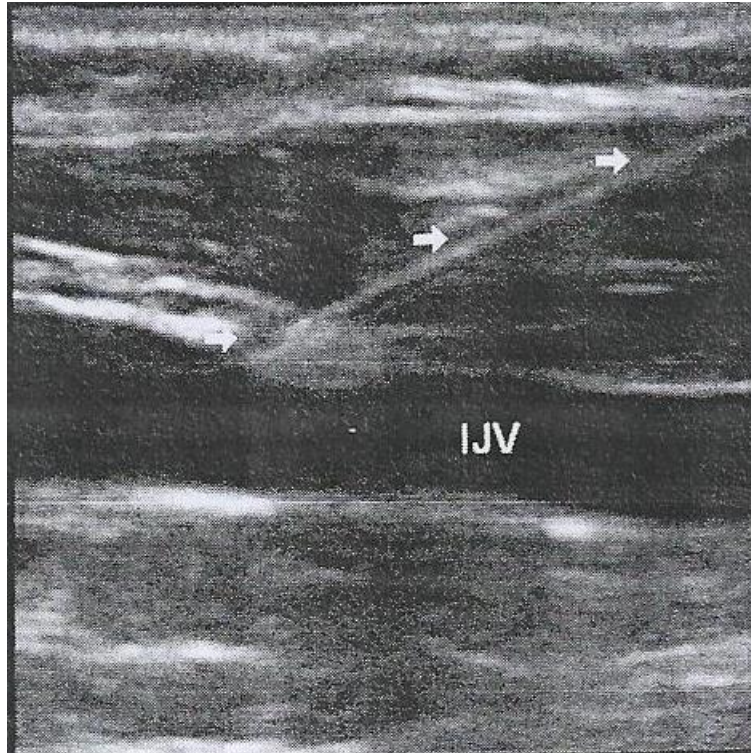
Ultrasound image showing long axis view of needle puncturing the internal jugular vein from the data collected
